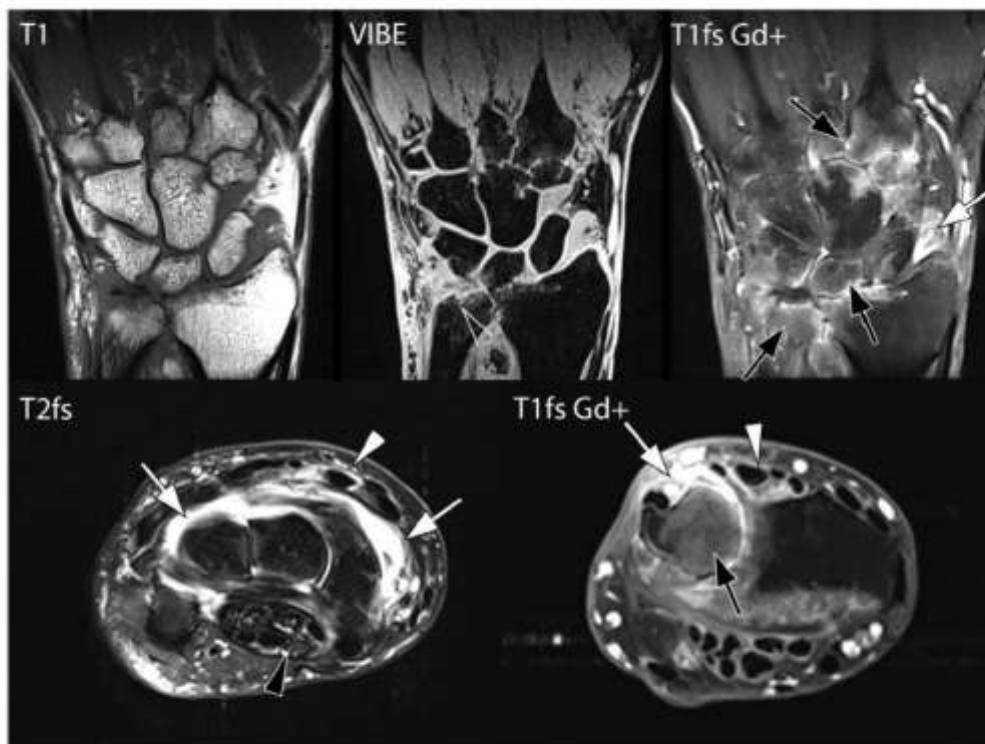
Wrist MR image of a 49-year-old man with dermatomyositis complicated by septic inflammation on immunosuppressive therapy. The images show active inflammatory changes: wrist joints with synovitis (white arrow), osteitis (black arrow), minor tenosynovitis in several compartments of extensor and flexor tendons (white arrowheads), and tendinopathy of deep flexor muscle of the fingers in the carpal tunnel (black arrowhead). Osteolytic lesions with cartilage loss of numerous bones are best appreciated on a volumetric interpolated breath-hold examination sequence.
